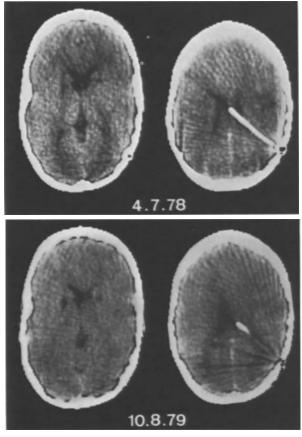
H.F., 9 years. Same patient. Minimal ventricular dilatation during a second period of shunt malfunction (*above*); CT control following successful shunt revision
